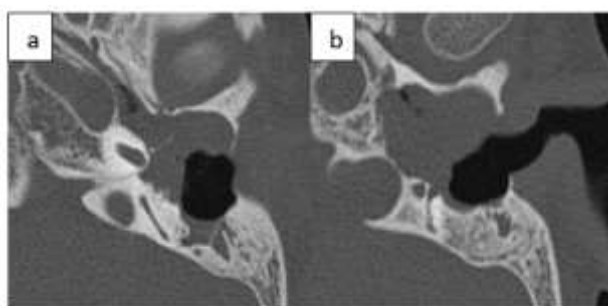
Temporal bone CT images showing EACC with posterior wall erosion and extension to mastoid air cells and FN canal, a) axial CT image showing erosion of the posterior wall of the EAC with involvement of the mastoid air cells; b) Axial CT image showing the extension to the FN canal.
